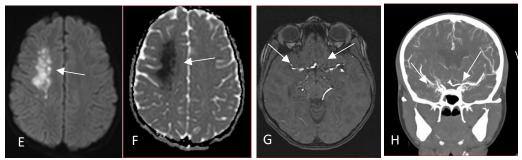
MRI (E-DWI, F-ADC and G-MRA) and CT angiographic (H) images of the patient showing presence of occlusive changes in bilateral (Right >Left) as shown by white arrows. The MR images E and F shows presence of infarct in right MCA territory region of brain.
